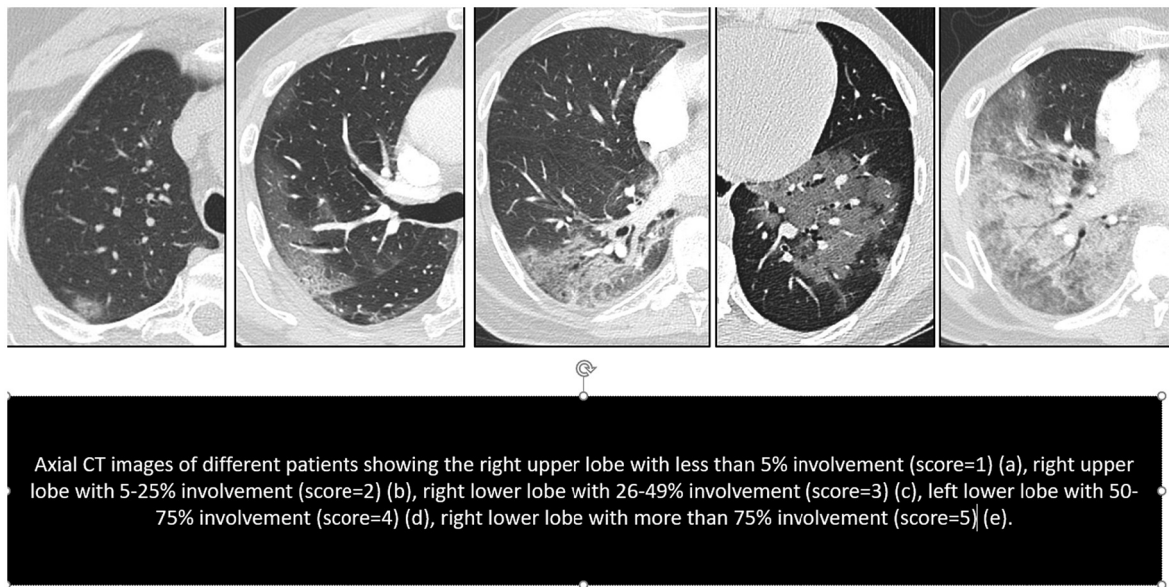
Axial CT images showing lobar lung involvement and the assigned score.
